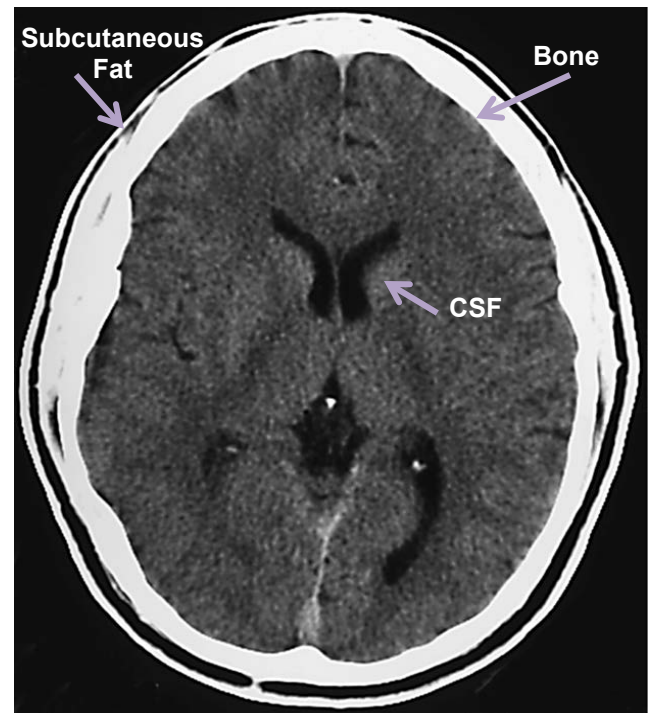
Axial CT image of the brain.
